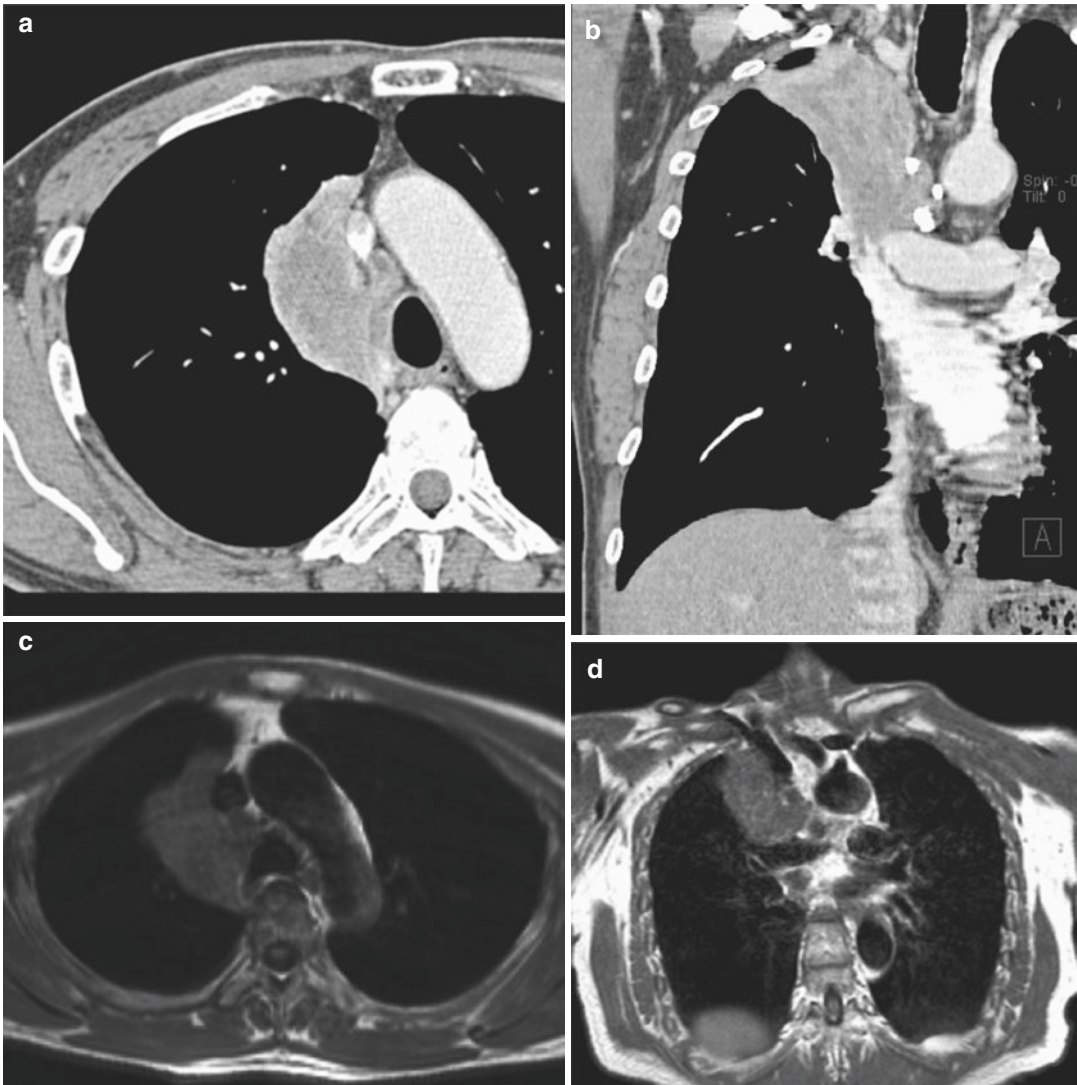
A 61-year-old male with squamous cell carcinoma in the right upper lobe. Contrast-enhanced CT (a) suggests mediastinal invasion, while contrast-enhanced coronal reformat (b) clearly demonstrates mediastinal
